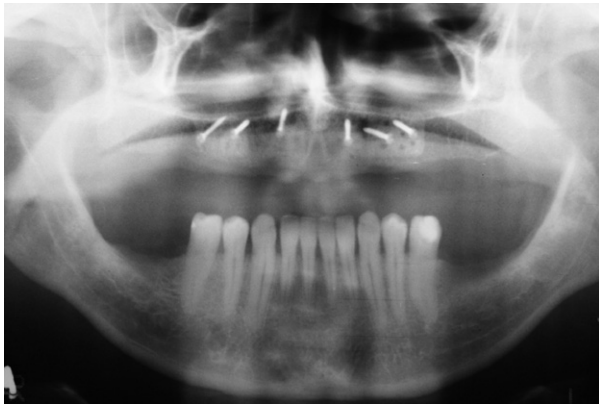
Panoramic radiograph showing graft incorporation.
